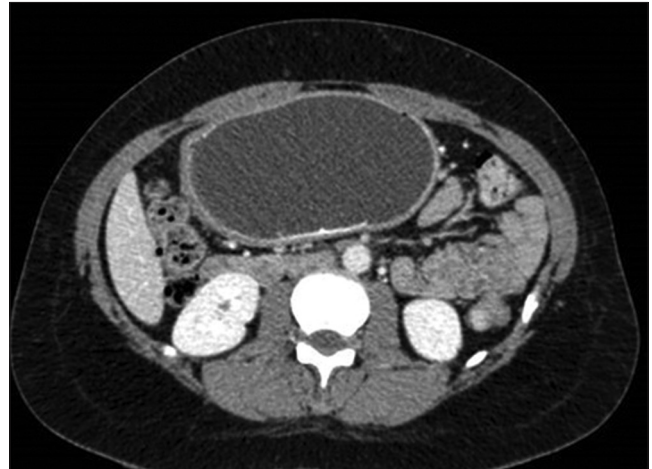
Axial CT scan shows large intra-abdominal mass corresponding to a gastric balloon compressing the inferior vena cava.
